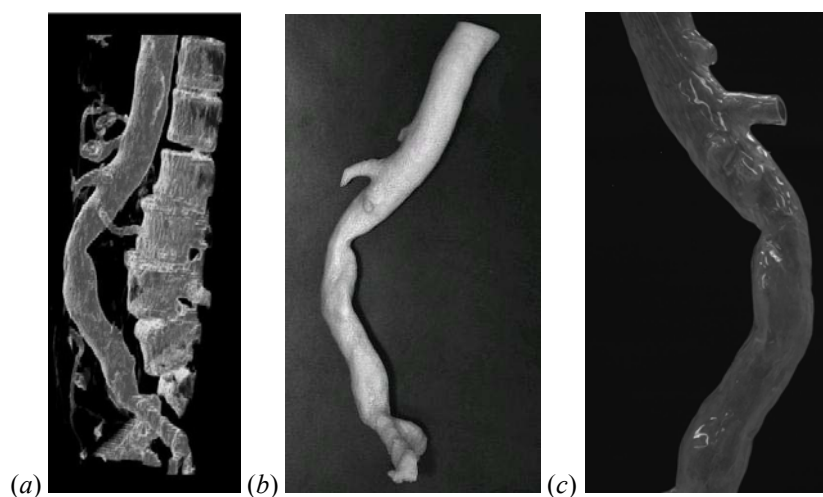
(a) Three-dimensional reconstruction of an AAA from CT scan images, (b) mold generated in plaster of Paris with a rapid prototyping technique, (c) silicone model built from the mold using a lost wax technique.
